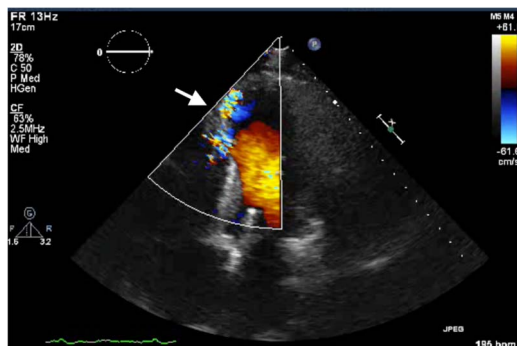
Transthoracic echocardiography four-chamber view of the postmyocardial infarction ventricular septal rupture (arrow).
